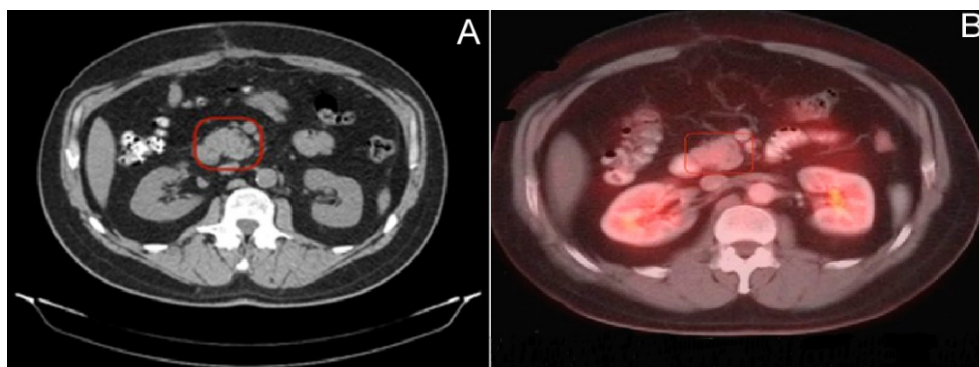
A. Contrast-enhanced CT scan, axial section. A nodular image is visible to the right of the superior mesenteric artery, indicating lymph node metastasis. B. PET/CT-FDG axial section. Same image without abnormal uptake.
